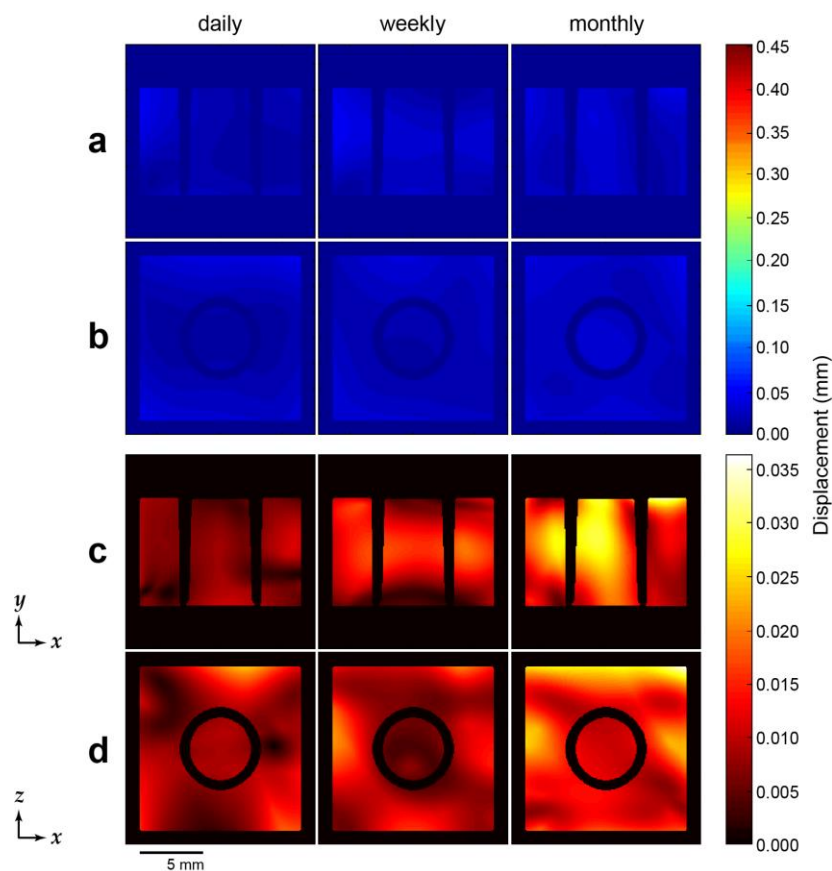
Deformation in repeated MRI.
